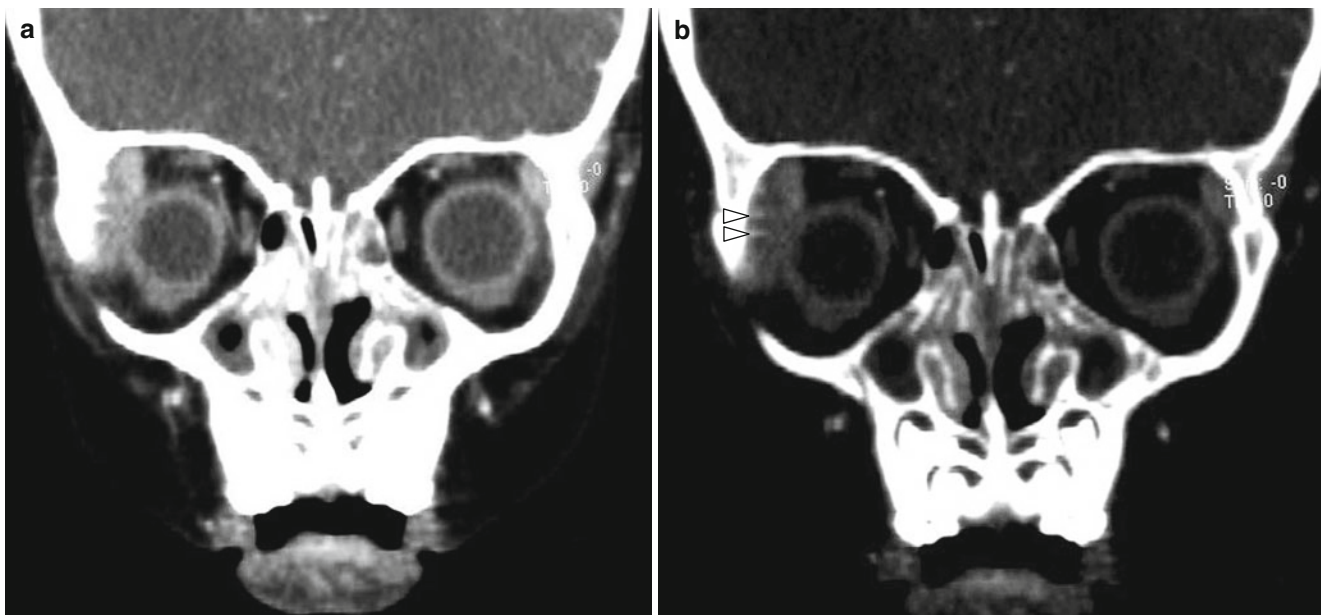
Metastatic neuroblastoma in a 2-year-old boy. (a) Contrast-enhanced coronal CT scan shows a homogeneously enhancing soft tissue mass involving the superolateral wall of the right orbit. (b) CT scan
